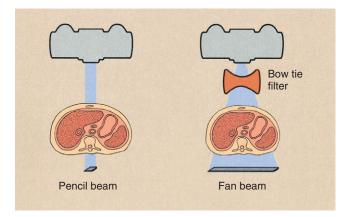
Profiles of two x-ray beams used in computed tomography (CT) imaging. With the fan-shaped beam of second generation, a bow-tie filter is used to equalize the radiation intensity that reaches the detector array. For first-generation CT, a pencil x-ray beam is used.
